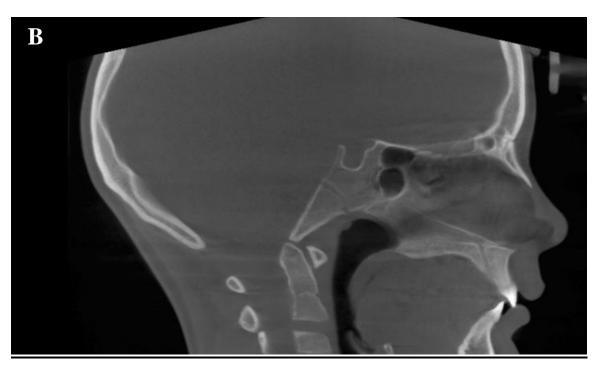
Pre-surgical (A) and post-surgical (B) CBCT scans revealing decreased airway space due to positioning of soft tissues
